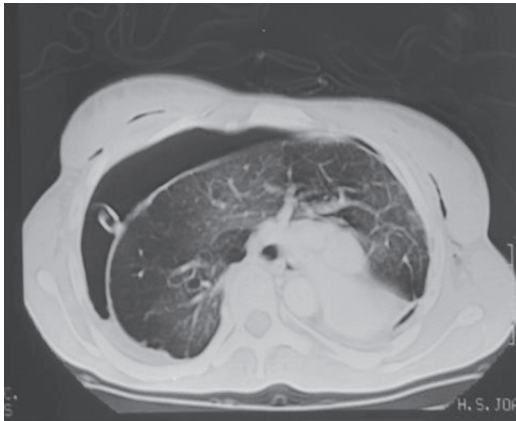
Thoracic CT scan demonstrating a single lung, herniated (“buffalo chest”)
